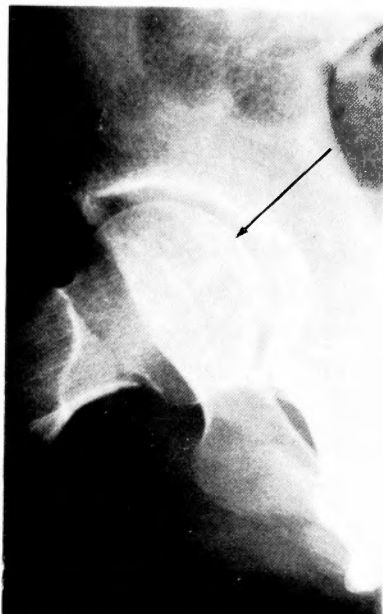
Roentgenogram in a lateral view shows a translucent subchondral band (arrowed).
